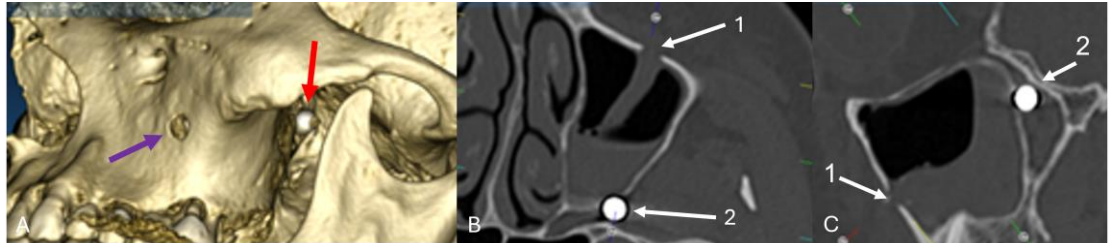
Trajectory of the bullet on CT scan. A. 3D reconstruction of the left maxillary sinus. Violet arrow: entry point. Red arrow: bullet in between the posterior wall of the left maxillary sinus and the left pterygopalatine fossa. B. Axial view. 1: entry point at the anterior wall of the left maxillary sinus. 2: bullet in between the posterior wall of the left maxillary sinus and the pterygopalatine fossa. C. Sagittal view. 1: entry point at the anterior wall of the left maxillary sinus. 2. Major part of the bullet is situated in the left pterygopalatine fossa.
